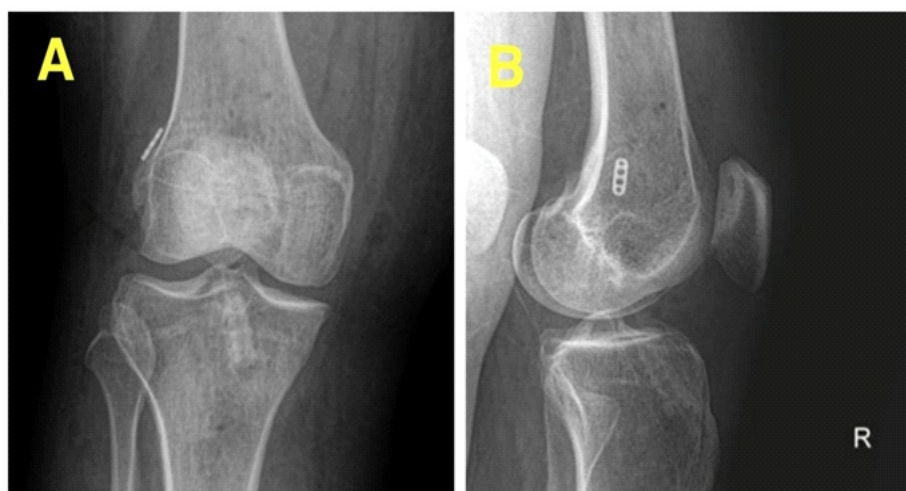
(a and b) Post-operative radiographs.
